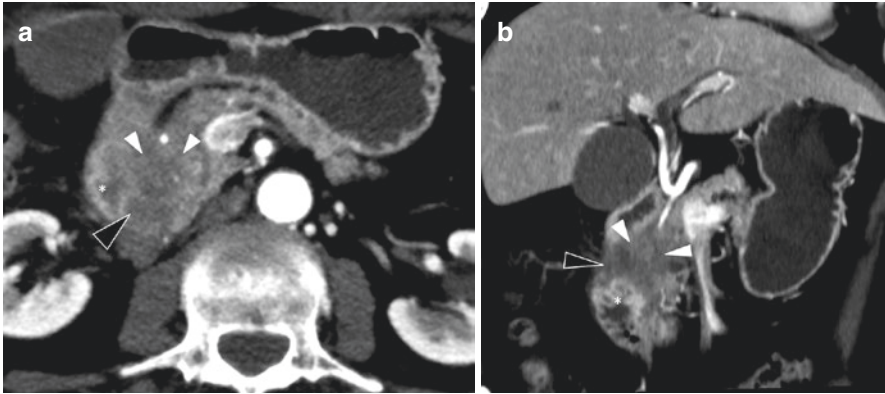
CT signs of duodenal involvement. CT with contrast injection at the pancreatic arterial phase, axial (a) view and coronal reconstruction (b): large tumor in the head of the pancreas (white arrows) with invasion of the wall of the second part of the duodenum (the black arrows indicate tumor spread and the asterisk the duodenum)
